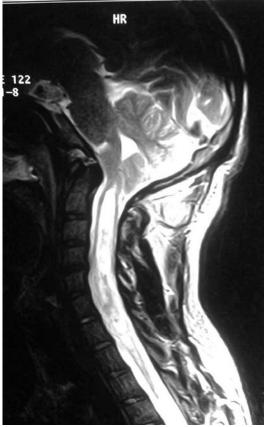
MRI spine showing post-TB meningitis multiloculated syrinx with cord atrophy
